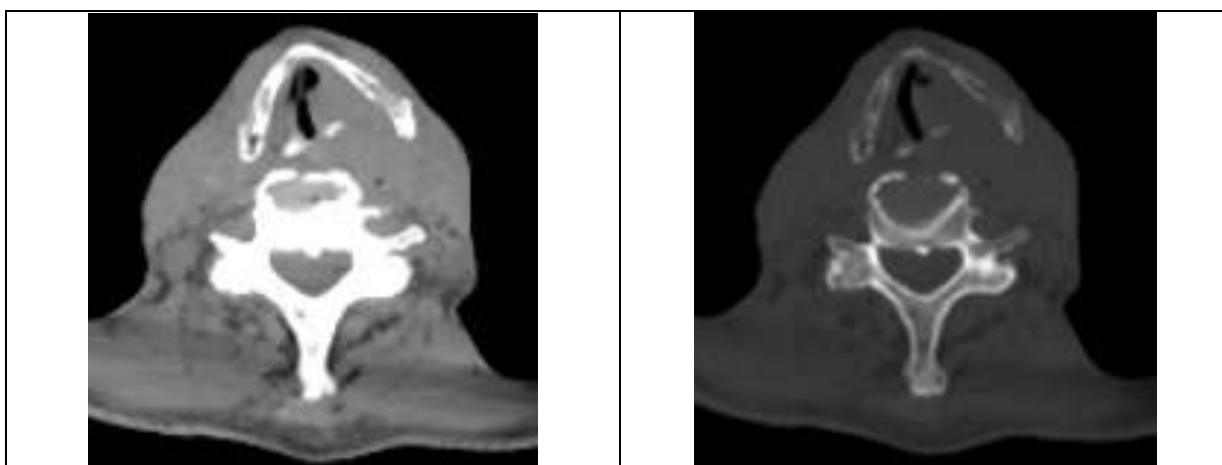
(a) and 8(b): Axial CT and CT bone images at the level of thyroid cartilage in a case of Ca supraglottis and transglottis shows erosions of left thyroid cartilage
